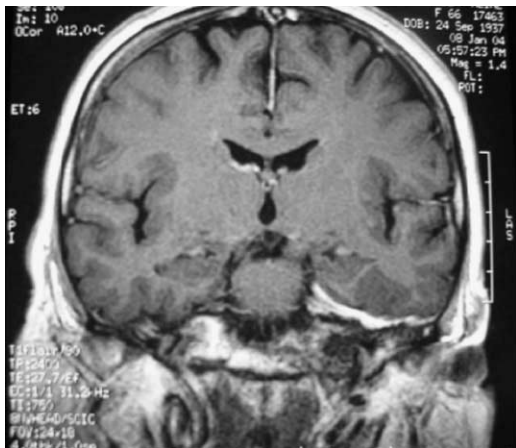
Coronal T1-weighted MR image after gadolinium injection showing the typical aspect of a left temporal *en plaque* meningioma (Case 3).
